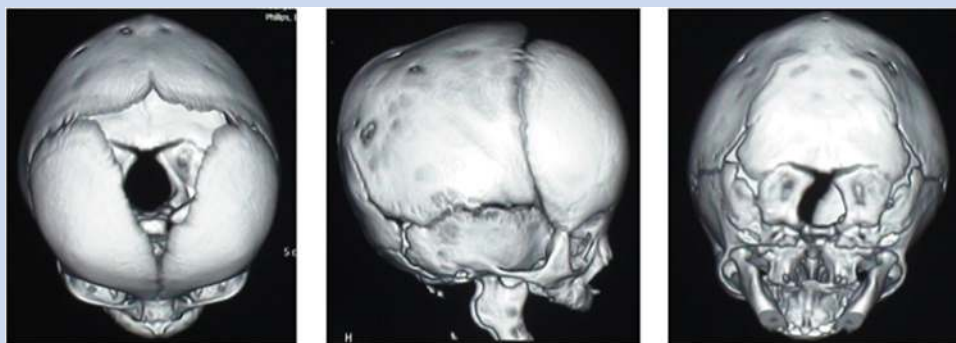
Three-dimensional computed tomography reconstruction of skull showing sagittal suture fusion.
